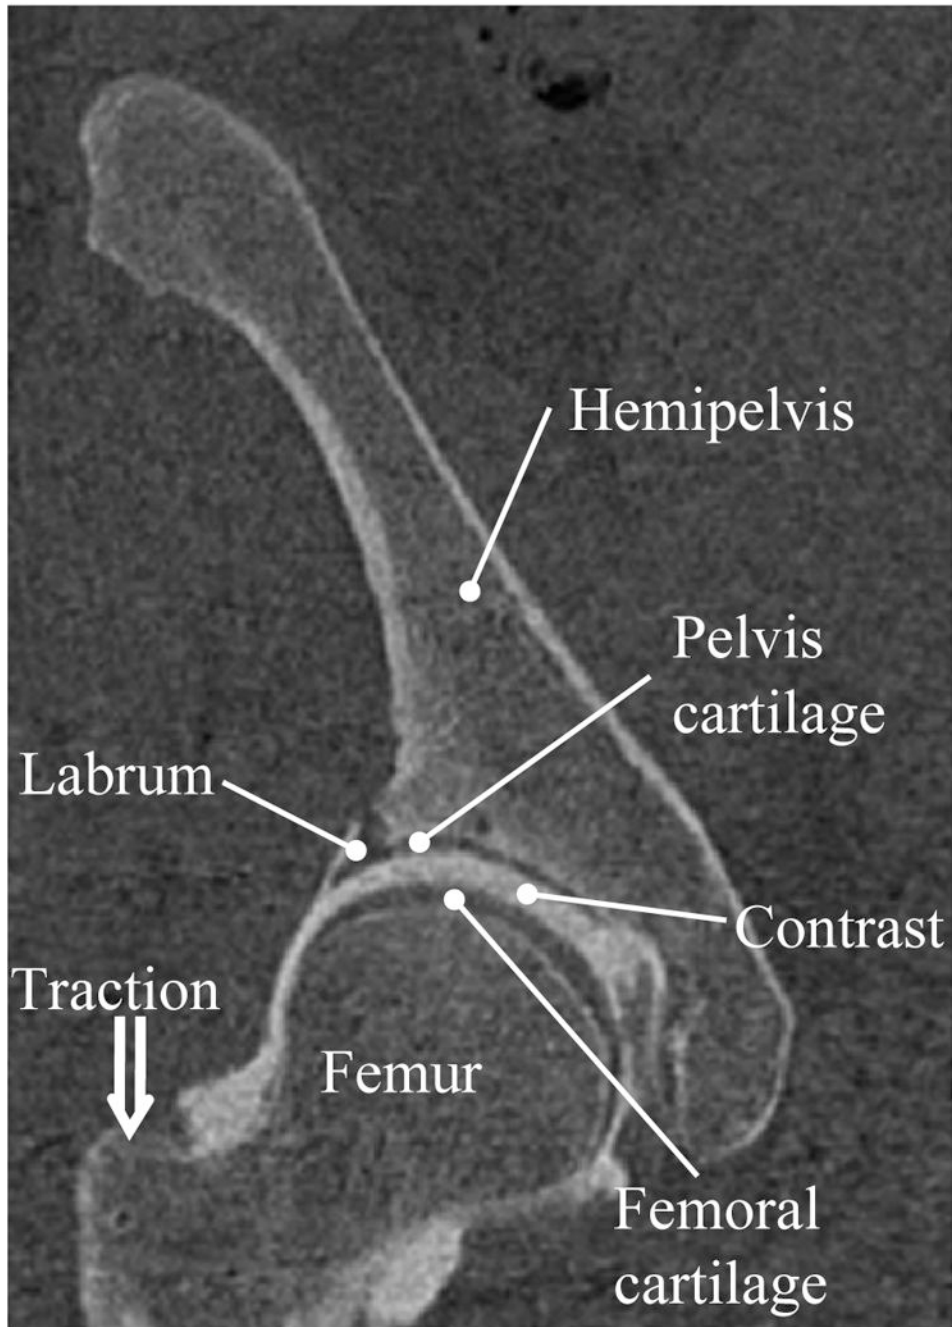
Coronal CT slice of the dysplasia patient. Structures of interest are highlighted.
